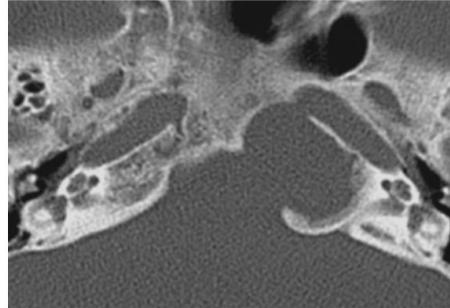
Normal petrous apex canals. (a) Axial MR image obtained with the constructive interference in the steady state (CISS) sequence shows the cisternal segments of the abducens nerves entering the skull base through the Dorello canals (arrowheads), which are located along the posteromedial walls of the petrous apices. The Meckel caves (arrows) can also be seen bilaterally, coursing over the superior margins of the petrous apices just anterolateral to the Dorello canals. (b) Axial CT image shows the subarcuate canal (arrow) coursing laterally in the superior portion of the petrous apex between the crura of the superior semicircular canal. The subarcuate canal can occasionally be mistaken for a fracture. (c) Axial CT image at the level of the IAC shows the singular canal (arrow), which extends from the posterior wall of the IAC to the ampulla of the posterior semicircular canal. Note also the pneumatized anterior portion of the petrous apex.
